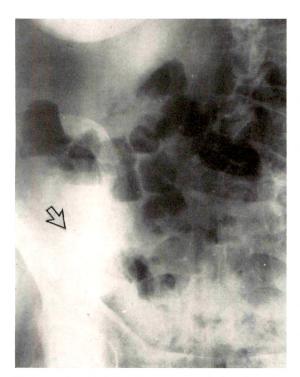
An erect roentgenogram of the abdomen demonstrates a coprolith in the right lower quadrant. There is an associated soft tissue haziness which is the result of the peri-appendiceal inflammatory reaction. The small bowel dilatation represents an associated localized ileus.
